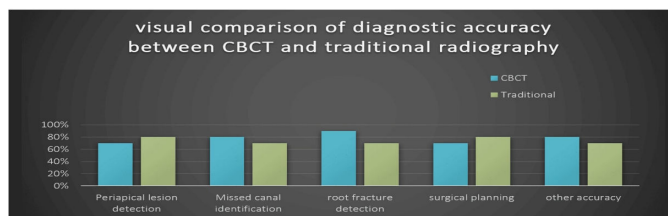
Visual comparison b/w CBCT and traditional radiography [25]
